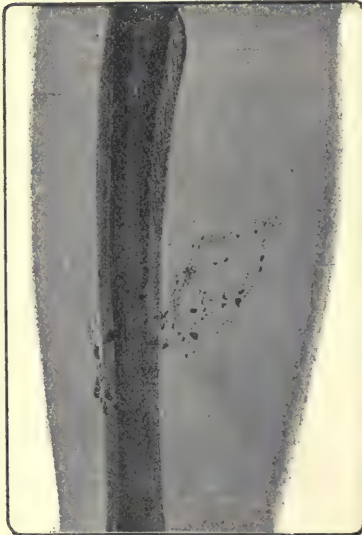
Radiograph of the left fore-arm seen from its ulnar side. A trail of metal dust will be noticed in the soft parts (grenade).
